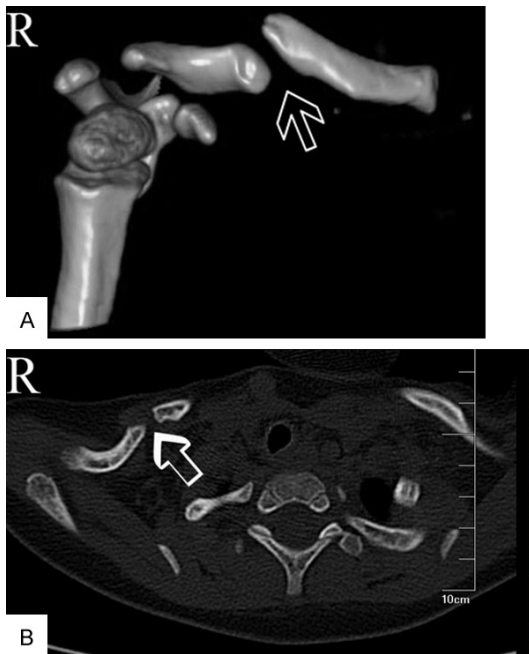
Preoperative appearance of the three-dimensional Computed Tomography scan (CT) of the clavicle. A: There was a discontinuous and displaced clavicle (arrow). B: Horizontal scans showed a discontinuous and displaced clavicle with soft tissue interposition (arrow).
